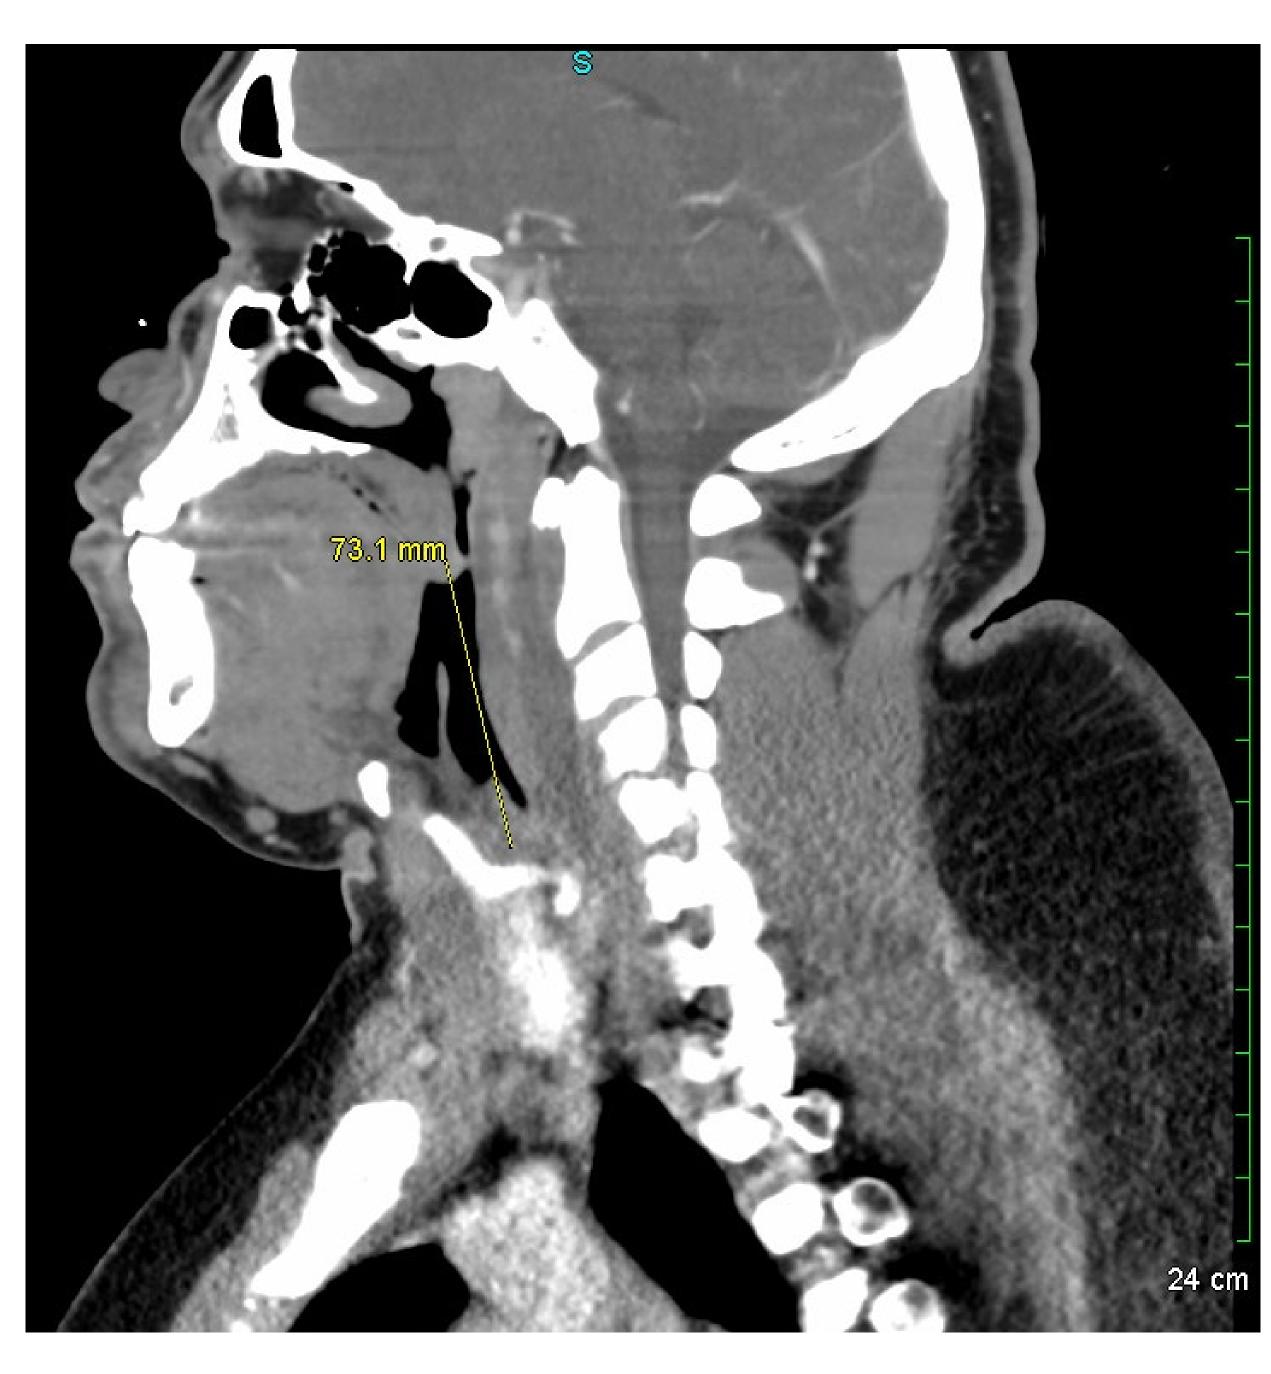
CT Soft Tissue Neck with Contrast Impression: Hypoattenuating fluid collection measuring $2.7 \times 1.3 \times 7.3$ cm in the retropharyngeal space with concern for extension into the interspace posteriorly, findings are concerning for retropharyngeal abscess.
